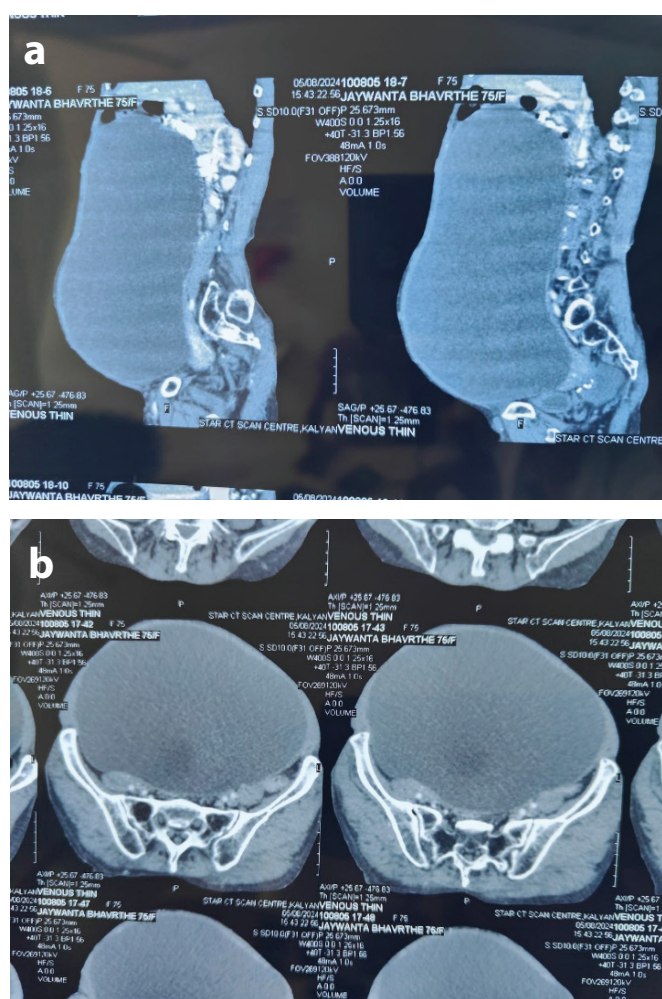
(a & b): CT scan abdomen – preoperative showing cyst in the abdomen.
